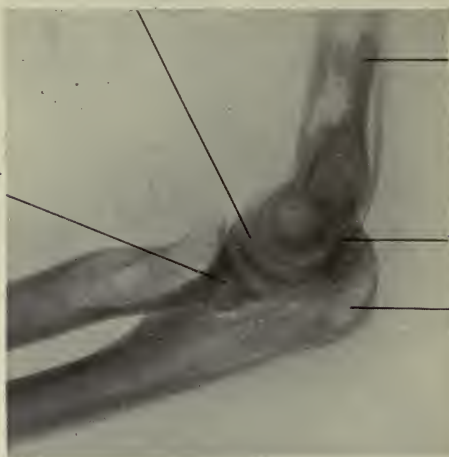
Lateral Radiograph of partly bent Elbow.
